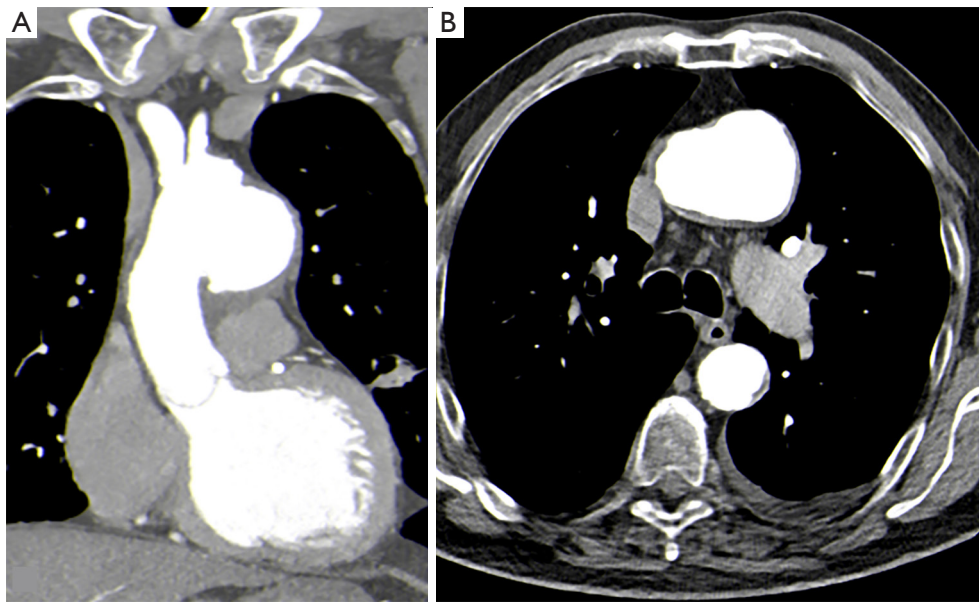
Preoperative computed tomography angiography of the thoracic aorta. (A) Coronal reconstruction demonstrating aortic arch pathology involving the ascending aorta and arch. (B) Axial view confirming the extent of the lesion and its relationship to the adjacent mediastinal structures.
